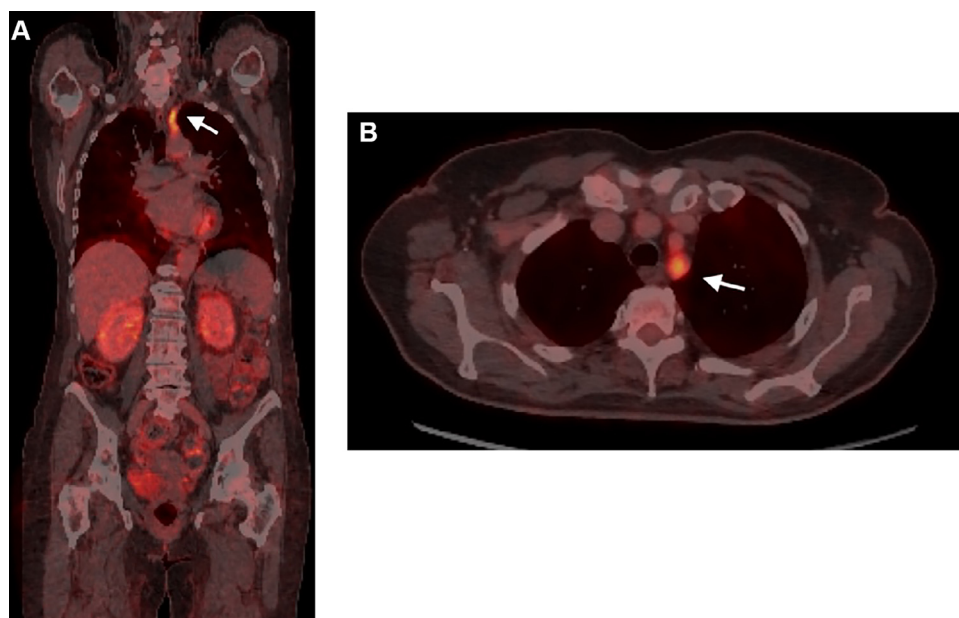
There was wall uptake at the origin of the left subclavian artery with a maximum standardized uptake value (SUV) of 4, suggesting the presence of inflammatory activity.
